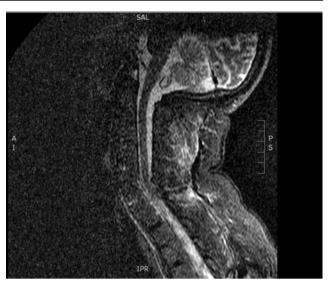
MRI of cervical spine. Lateral view showing spinal fracture between C7 and T1 vertebral bodies
